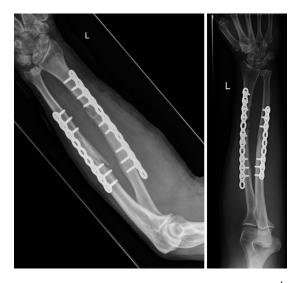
Plain radiographs demonstrate the 2nd revision surgery with iliac crest bone graft and exchange of plate fixation. Left: taken post-operatively on the day of surgery. Right: taken at 4.5 month post-operatively, demonstrating the persistent radial nonunion
